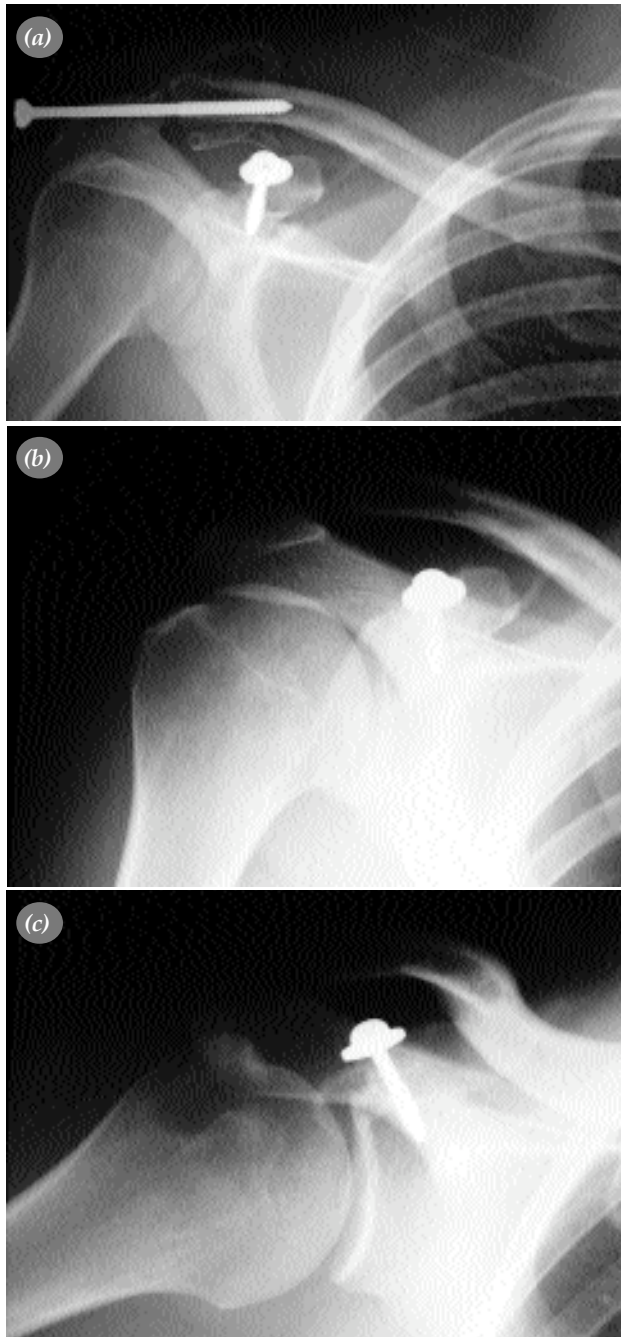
(a) Postoperative X-ray view. AC joint was fixed using Knowles pin and coracoid process was secured using 4.0-mm malleolar screw and washer. (b-c) X-Rays of the shoulder at first postoperative year after removal of the Knowles pin.
